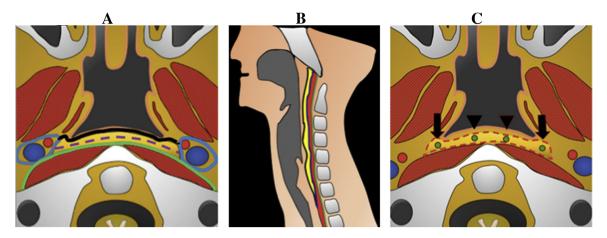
Normal anatomy of the RPS. Axial images containing CT show visceral fascia (black line), prevertebral fascia (green line), the carotid sheath (blue line), and the alar fascia (purple dashed line) (A). A sagittal image shows RPS (yellow area), and the danger space (red area) (B). Medial retropharyngeal nodes (arrowhead) and lateral retropharyngeal nodes (arrow) are shown in the RPS (C).
